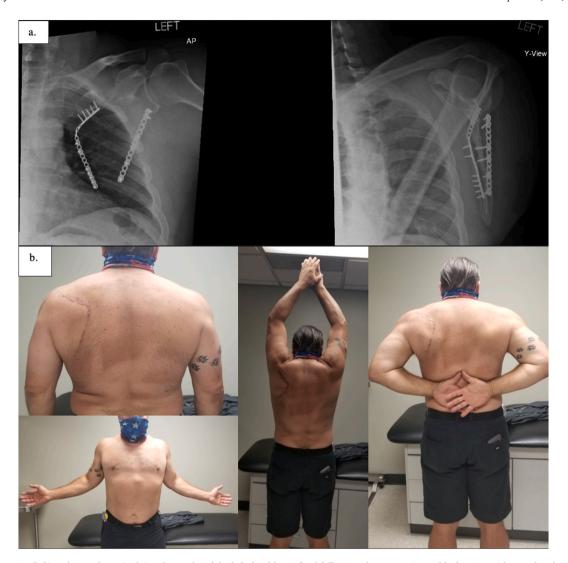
a: AP (left) and Scapular-Y (right) radiographs of the left shoulder at final follow-up demonstrating stable fixation with complete healing of the fracture.
